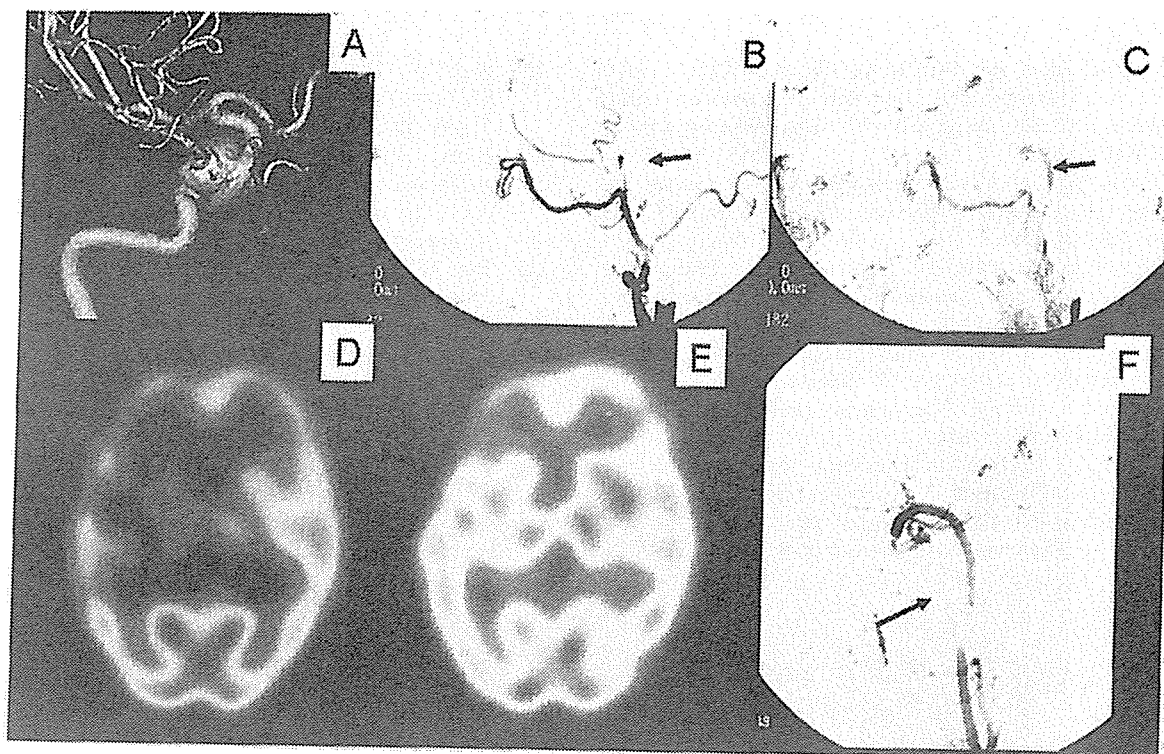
A 60-year-old woman who complained of diplopia due to right third cranial nerve palsy. A: A 3DDSA showing a large right ICA aneurysm at the cavernous portion. B (early phase) and C (late phase): Right common carotid angiograms during BTO showing opacification of petrous portion ICA (arrows) from branches of external carotid artery. D: An ECD SPECT during BTO of right ICA showing marked flow reduction in the right cerebral hemisphere (residual flow <70% of the contralateral region). E: An IMP SPECT obtained next day of the surgery showing sufficient flow in the right cerebral hemisphere. F: An angiography after surgery of external carotid-right middle cerebral artery bypass using saphenous vein graft and intravascular embolization (arrow) of right ICA just above the collateral flow shown in B and C.
